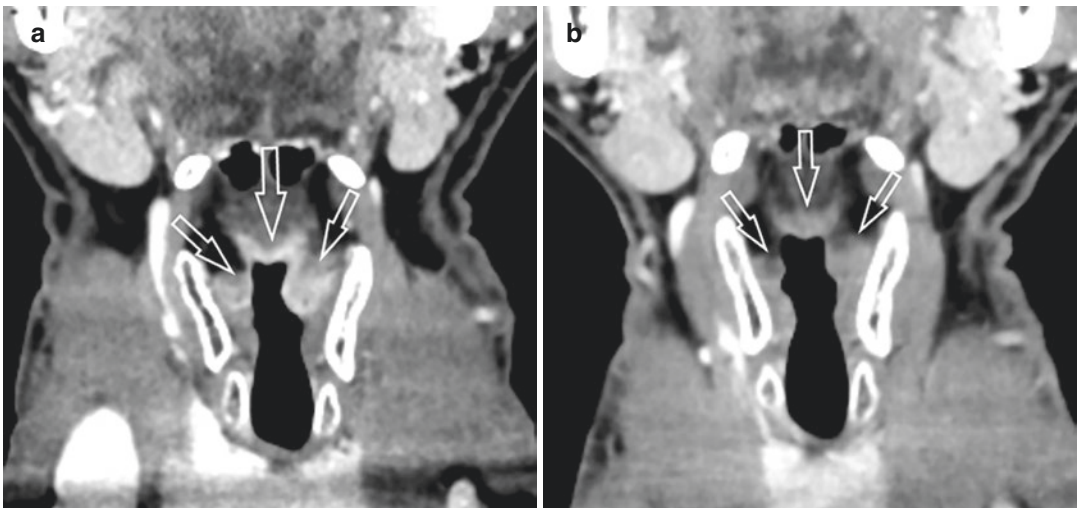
Diffuse enhancement in laryngeal tuberculosis. (a) Coronal contrast-enhanced CT image shows diffuse, bilateral, pronounced enhancement of the supraglottis
